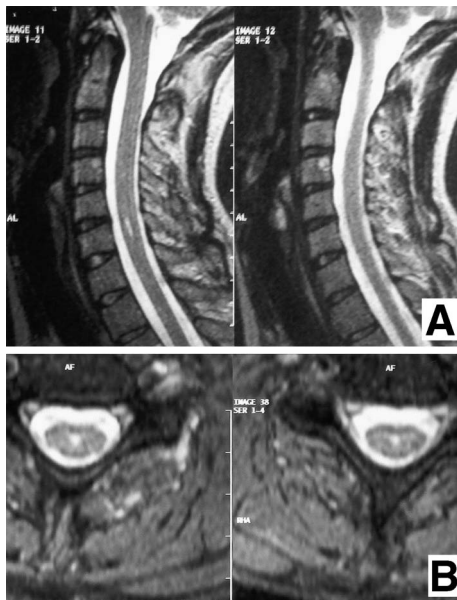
Midline sagittal (A) and axial (B) T₂-weighted magnetic resonance images obtained 6 years later showing almost complete resolution of the syringomyelic cavity.
